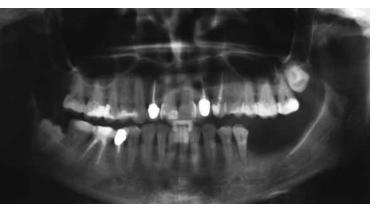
Pre-operative panoramic radiograph of tooth 34.
